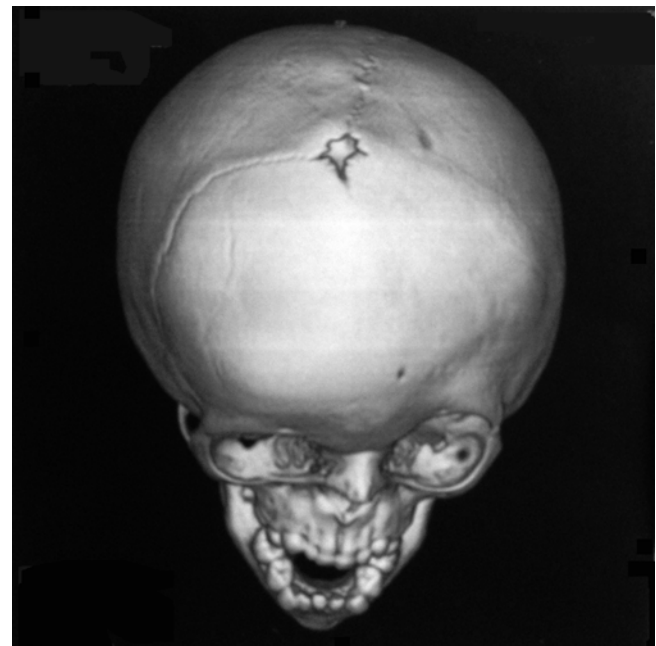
Three-dimensional CT scan of a patient with coronal synostosis
